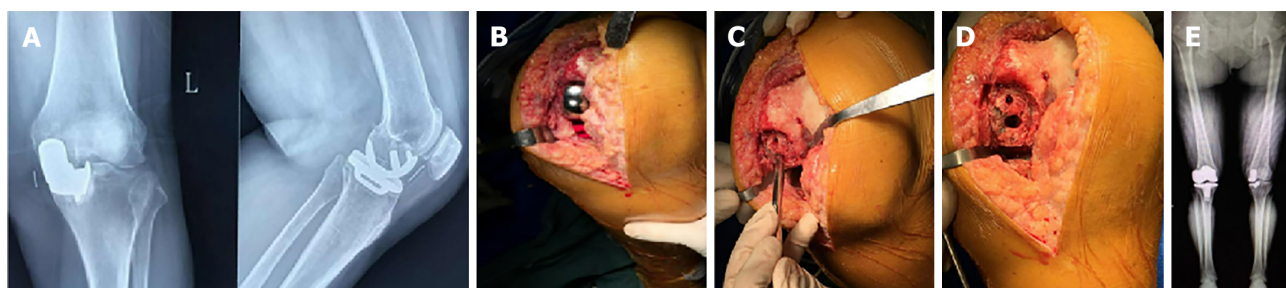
Treatment process (left knee) for Patient 12. A: Before revision, X-ray showed that the gasket was dislocated; B: The spacer was moved forward under extreme knee flexion; C: The centre of the femoral prosthesis was inwards; D: Prosthesis displacement; E: X-ray after revision.
